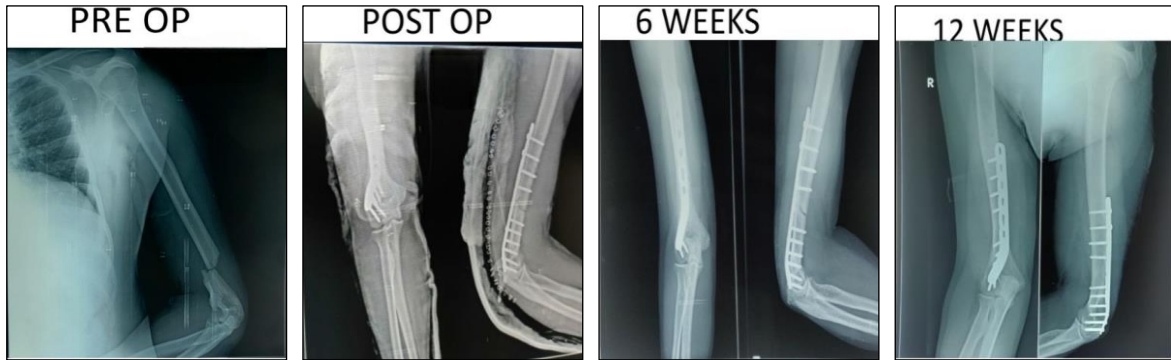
Showing Pre and Post-operative X-rays
